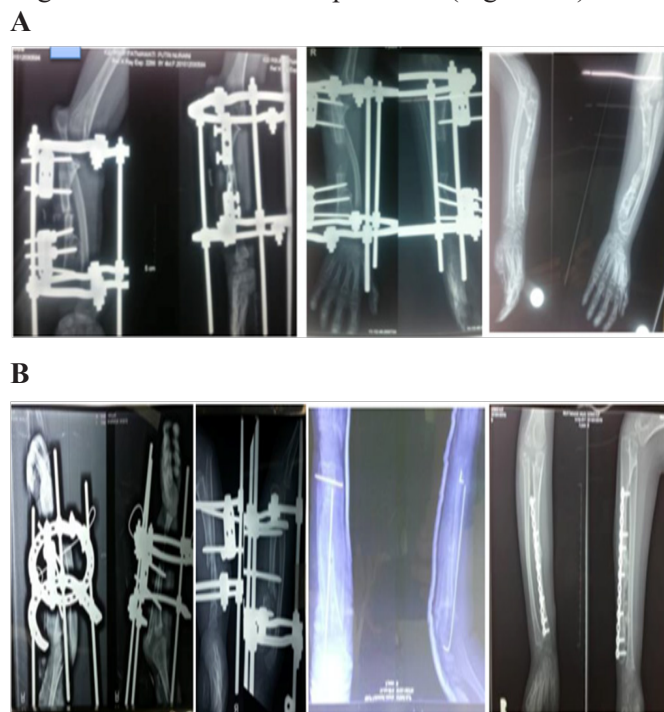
A Right forearm radiograph of patient 1 shows the sequences of correction until complete healing of the osteotomy sites with reduced radial head B. Radiographs of patient 2 shows the sequences of correction, ulnar lengthening with reduced radial head facilitated by transfixing wire on distal radius ulna, followed by conversion of ilizarov frame into internal fixation.
